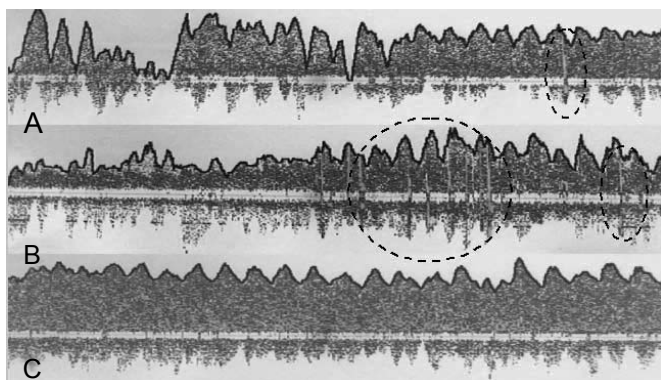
Intraoperative transcranial Doppler study of MCA. Episodes of microembolism (outlined) into MCA territory caused by passing the cerebral filter through stenosis area (a), stent placement and expanding (b). Good MCA blood flow after implantation (c).
